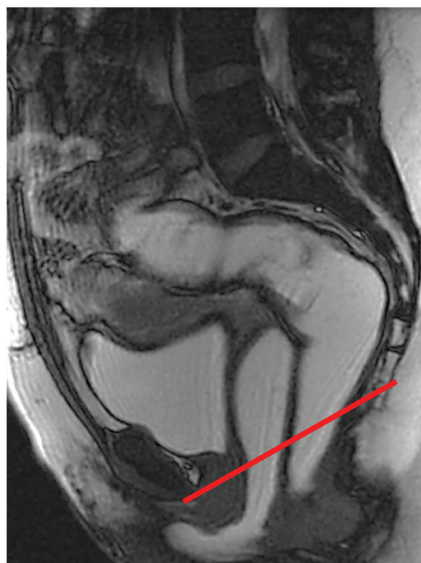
Dynamic examination of the female pelvic floor with FIESTA sequence. Sagittal T2-weighted MR images obtained with the patient at rest (a), squeezing (b), performing the Valsalva maneuver (c), and defecating (d). The red line indicates the pubococcygeal line (PCL). Defecography is crucial for better grading and assessment of prolapse. Although patients are instructed on how to perform the maneuvers before the examination, many of them cannot perform a proper Valsalva maneuver when asked to do so. In such cases, diagnosis of cystocele, rectocele (\* in d), or DPS is possible during defecography only.
